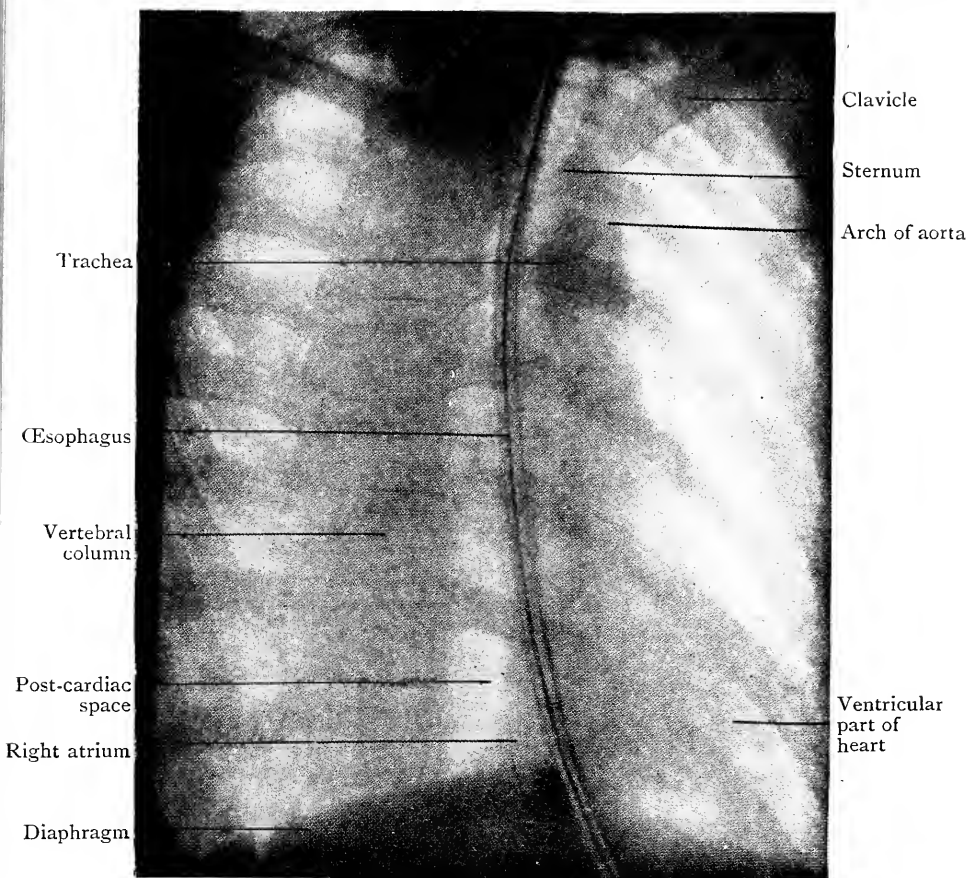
Radiograph of Thorax. Oblique view showing the "post-cardiac space."
